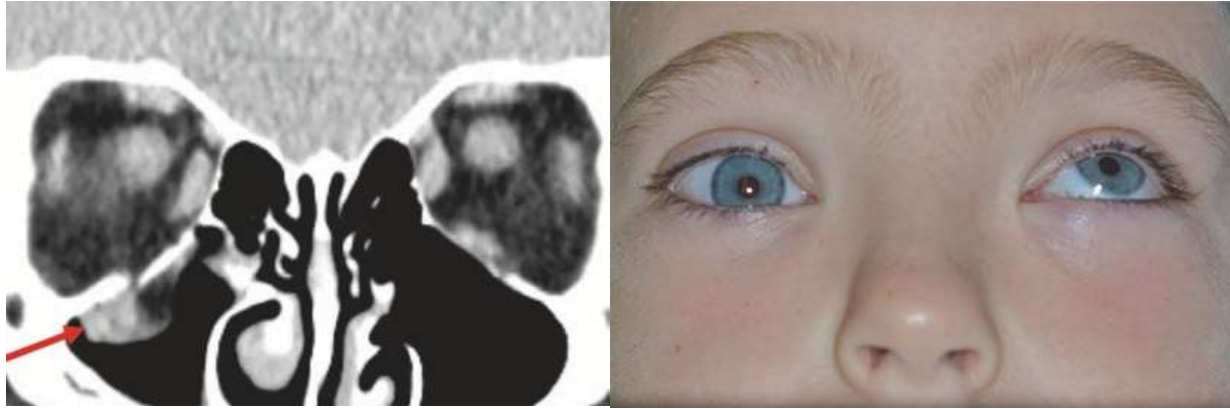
Coronal CT scan view of a pediatric trap door fracture in which the size of the orbital tissue herniating into the maxillary sinus is much smaller than the hole in the orbital floor. The inferior rectus muscle lies beneath the plane of the orbital floor (red arrow) (a). Marked restriction in upward gaze results (b) (Shinder, 2020).
